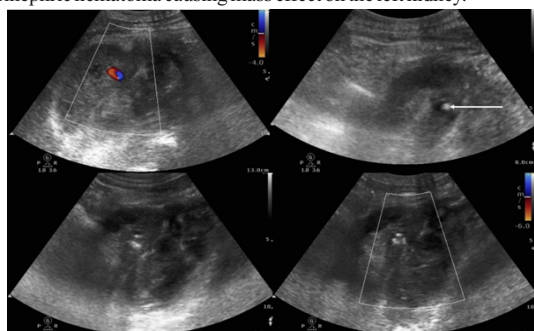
Color Doppler Sonography shows a pseudoaneurysm sac with ying-yang color flow pattern. The sac was punctured with a 22G spinal needle (arrow) and thrombin was injected. Post injection there was complete obliteration of the aneurysmal sac.
